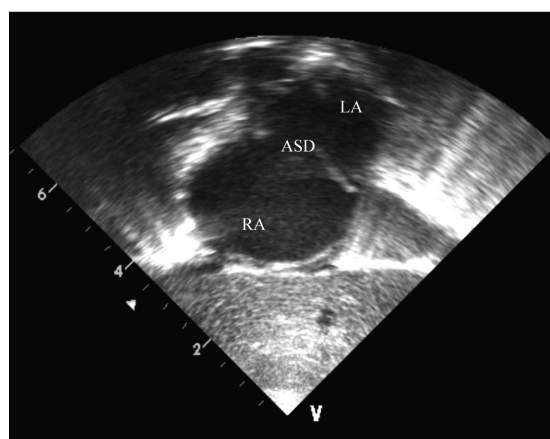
2D echocardiogram (subcostal view) taken on Day 2 of life shows a moderate secundum atrial septal defect. LA: left atrium; RA: right atrium; ASD: atrial septal defect
